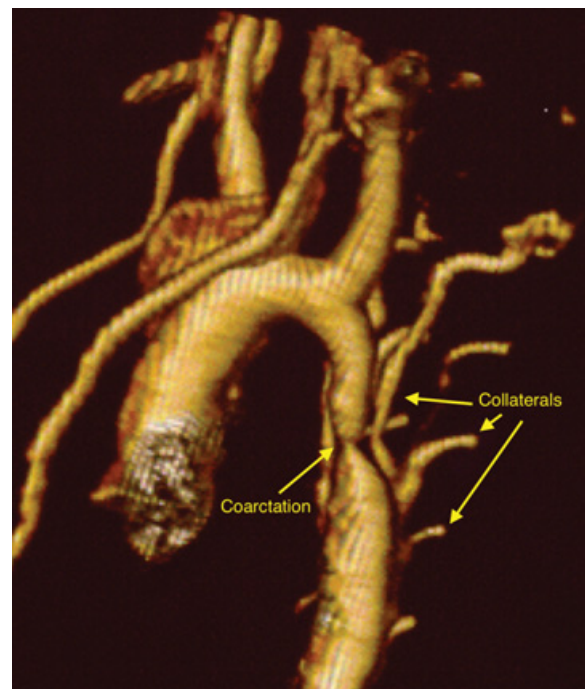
Coarctation of the aorta. 3D magnetic resonance imaging of juxtaductal coarctation of the aorta. There are multiple collaterals from the head and neck vessels that flow toward the descending aorta and effectively bypass the aortic narrowing. Courtesy of Michael Taylor, MD.
